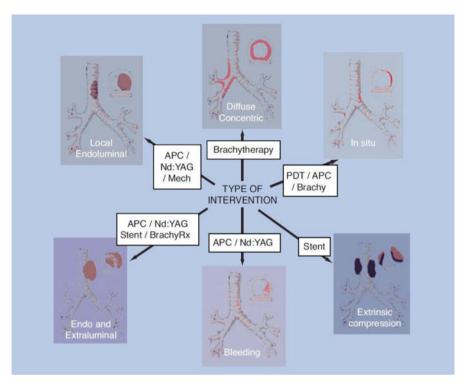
Interventional bronchoscopic therapy for airway obstructions. *APC* argon plasma coagulation, *Nd:YAG* neodymium-doped yttrium aluminum garnet, *Mech* mechanical ventilation, *PDT* photodynamic therapy, *Brachy* brachytherapy, *BrachyRx* brachytherapy. [Taken from Shannon VR et al. Respiratory complications. Chapter 131 in: *Cancer Medicine*, 8th edition. Hong WK, Bast RC Jr, Hait WN, Kufe DW, Pollock RE, Weichselbaum RR, Holland JF, Frei E III, eds. Shelton, CT: PMPH-USA, LTD. Used with permission from the People's Publishing House-USA.]
